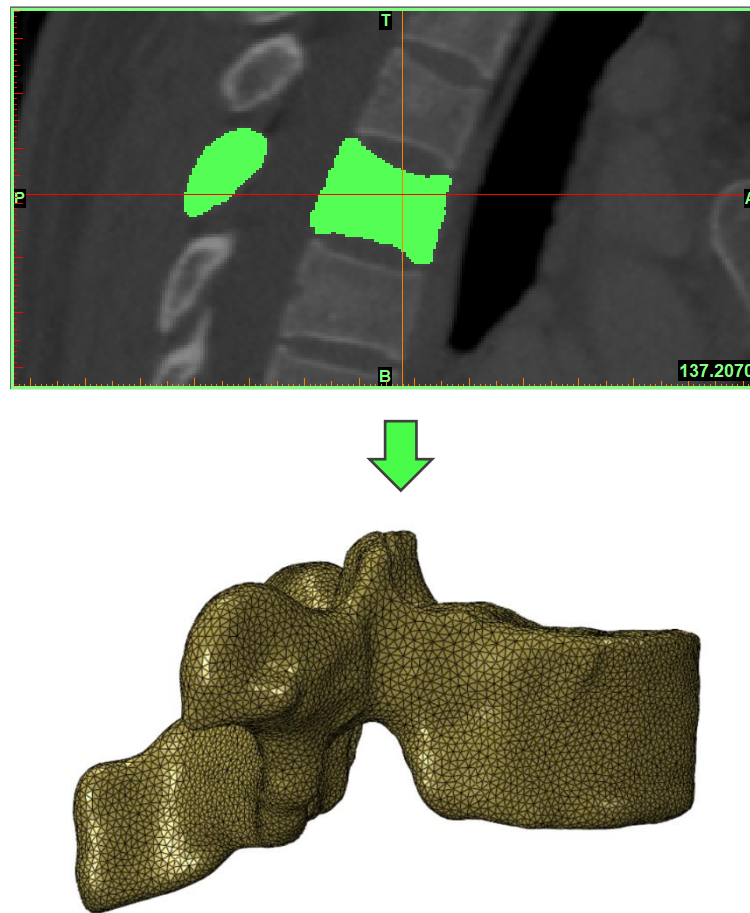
Modelling process from 2D medical CT scan in sagittal view (upper) to 3D thoracic vertebra model (down)
